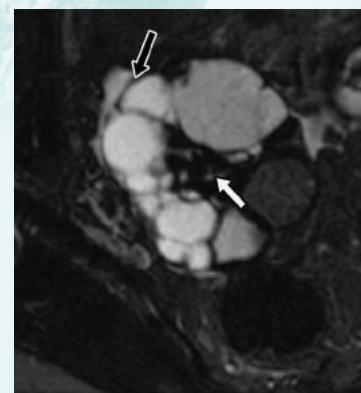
Cystadenofibroma: T2-w MRI scan showing a complex cystic mass with hypointense fibrous components (black arrow) and thick low signal septal walls (white arrows).
